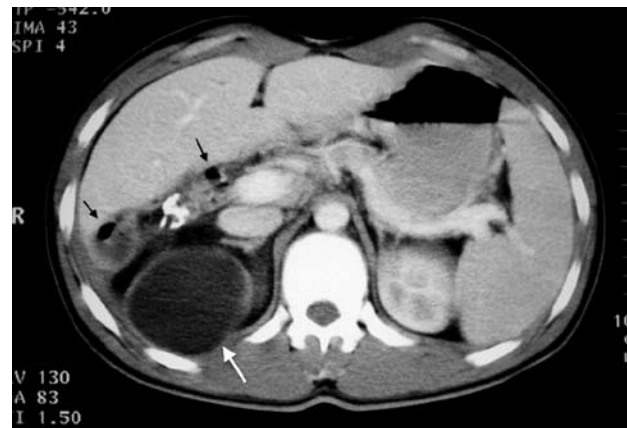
Upper abdominal CT section of a 21-year-old man with a relapsing hydatid cyst showing remnants and calcifications of the cyst in the right liver lobe. A large hydatid cyst of the upper pole of the right kidney (white arrow) was an incidental finding.
